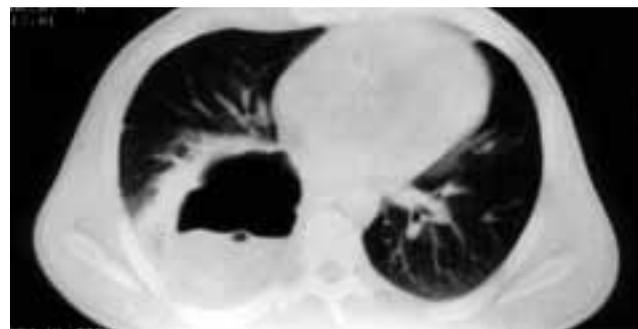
Computed tomography of the chest showing a ruptured echinococcal cyst in the right lower lung field with the cystic membrane floating on the hydatid fluid.
